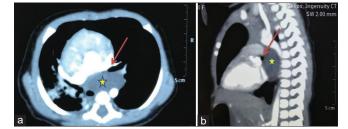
Computed tomography thorax: (a) axial view and (b) sagittal view showing a posterior mediastinal cyst (star) causing focal attenuation of the left main bronchus (arrow), resulting in hyperinflation of both the lobes of the left lung with the mediastinal shift toward the right
